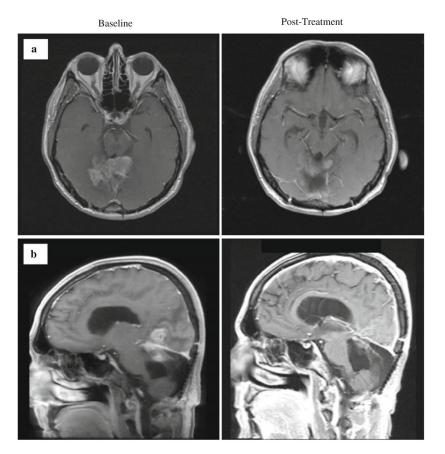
Magnetic resonance imaging demonstrating a partial response of a patient with recurrent atypical (grade II) meningioma following four cycles of bevacizumab with daily oral etoposide. The patient (Patient 13, Table 1) initially presented with grade I fibroblastic meningioma treated with resection, adjuvant imatinib/hydroxyurea, and then temozolomide following first progression and did not receive prior radiotherapy. a Post-contrast axial T1-weighted images. b Post-contrast sagittal T1-weighted images
